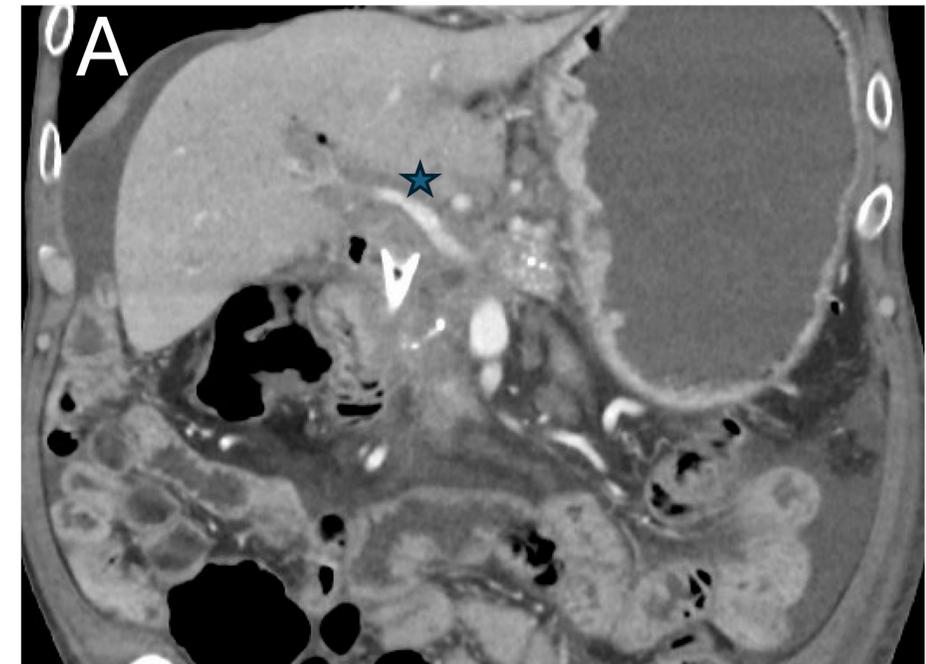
CT with contrast in coronal view. Portal vein is seen (below star) with surrounding fibrotic tissue.
